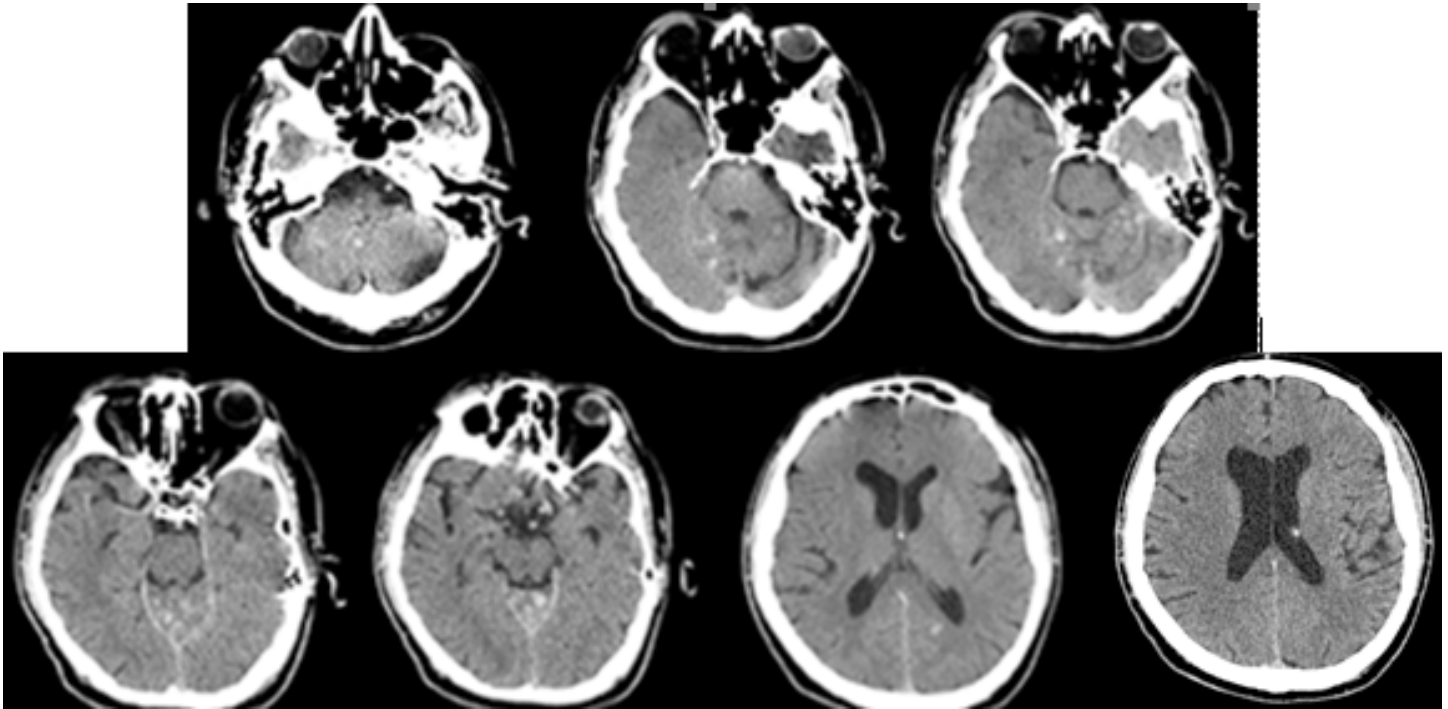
Control CT /17.05.21 -Brain leptomeningeal metastases sub-and supratentorially with dimensions up to 10mm (Figure 23).
